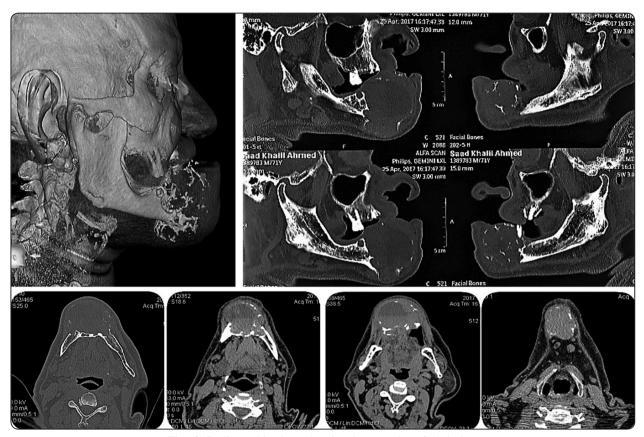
Radiographic views showing the extension of the lesion.
